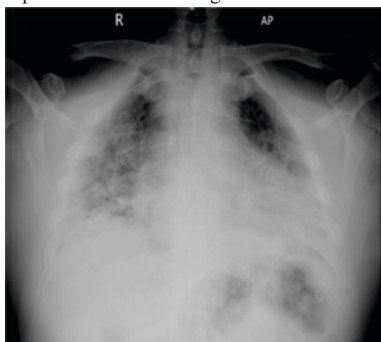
Chest xray AP view showing predominant reticular opacities in both lung fields
